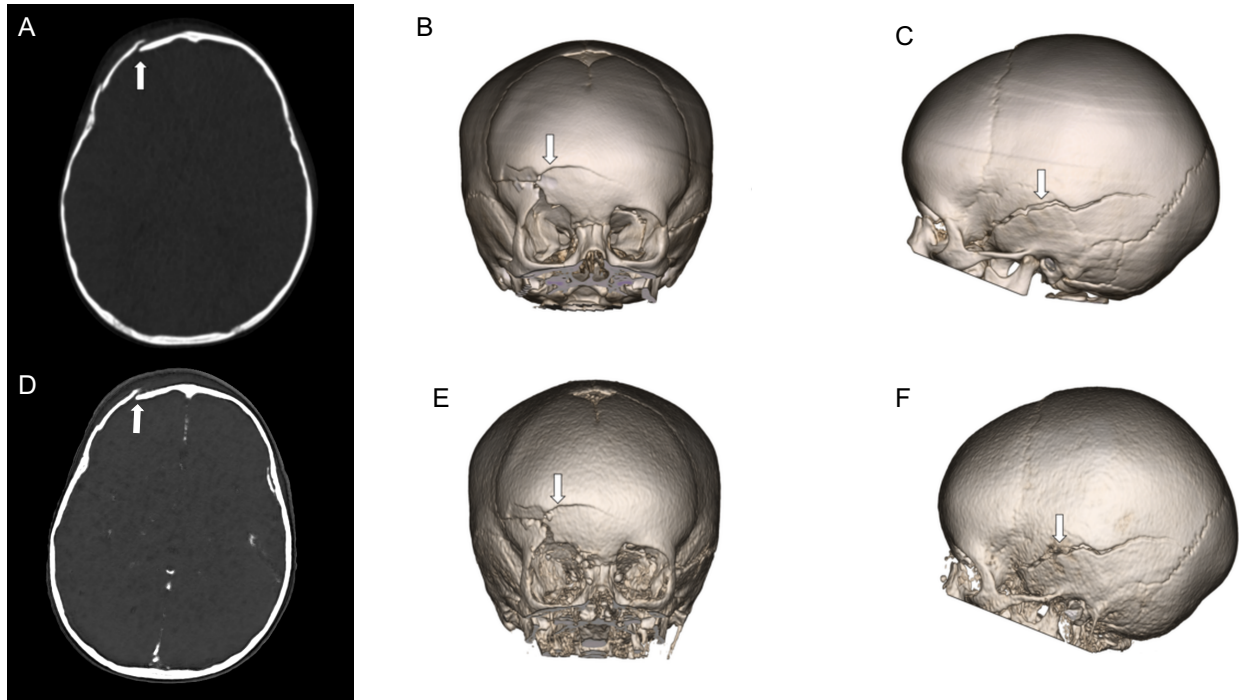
1.6 years old, multiple bone fractures. Arrows indicate fracture. CT axial volumetric sample (A). CT 3D-reconstruction (B, C). pCT axial volumetric sample (D) and pCT 3D-reconstruction (E, F).
